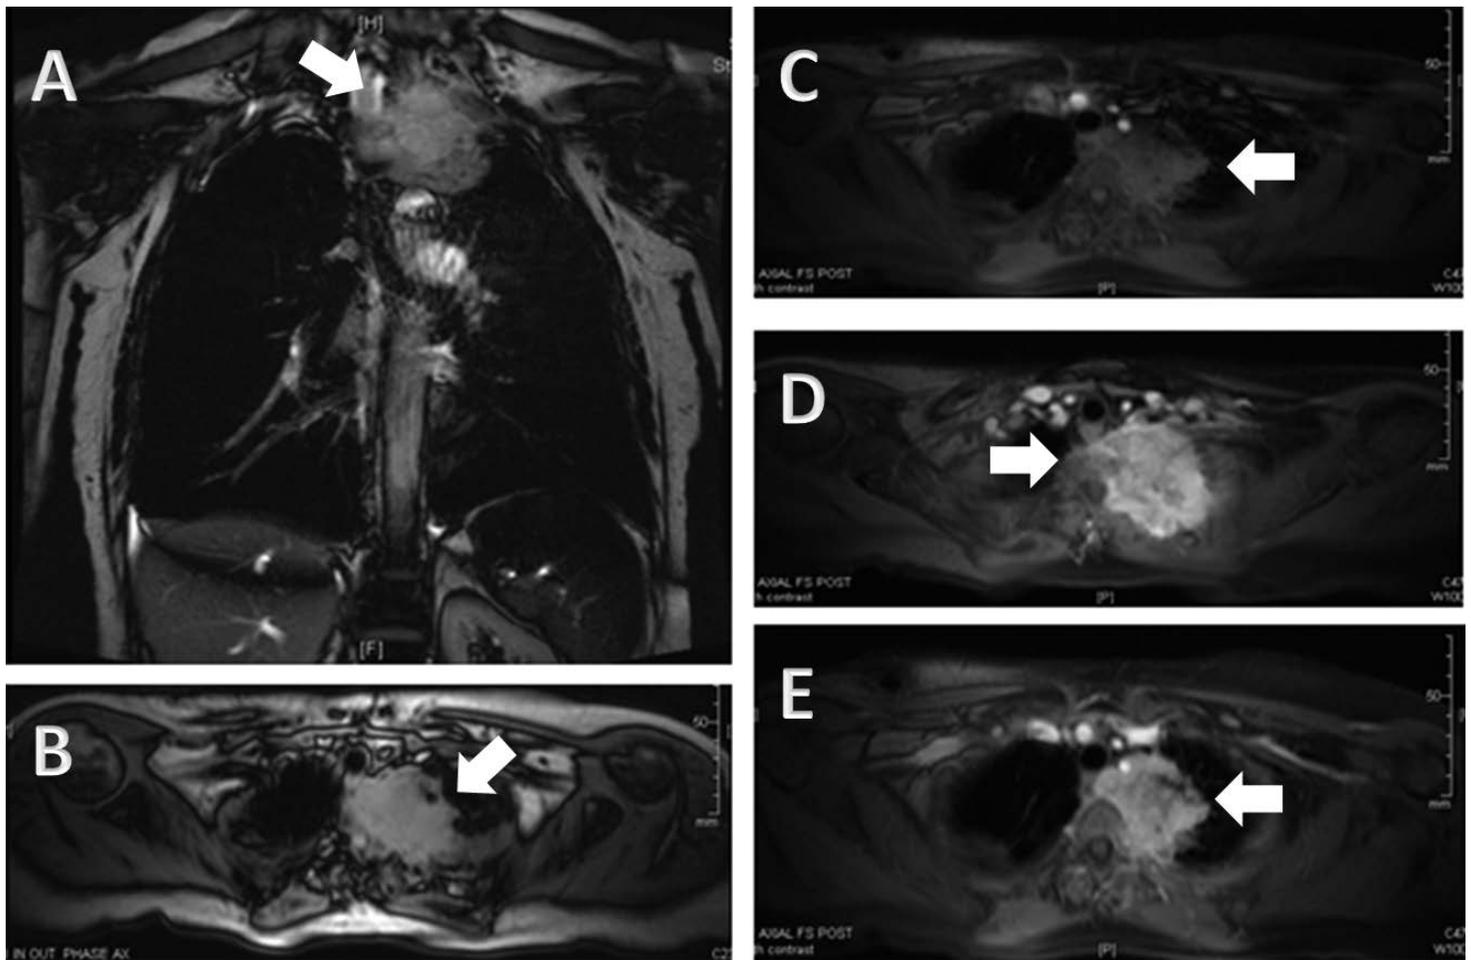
Preoperative magnetic resonance imaging showing mass (white arrows) in the left upper lobe involving (A) the adjacent thoracic vertebrae and (B-D) soft tissue and (E) abutting the takeoff of the left subclavian artery.
